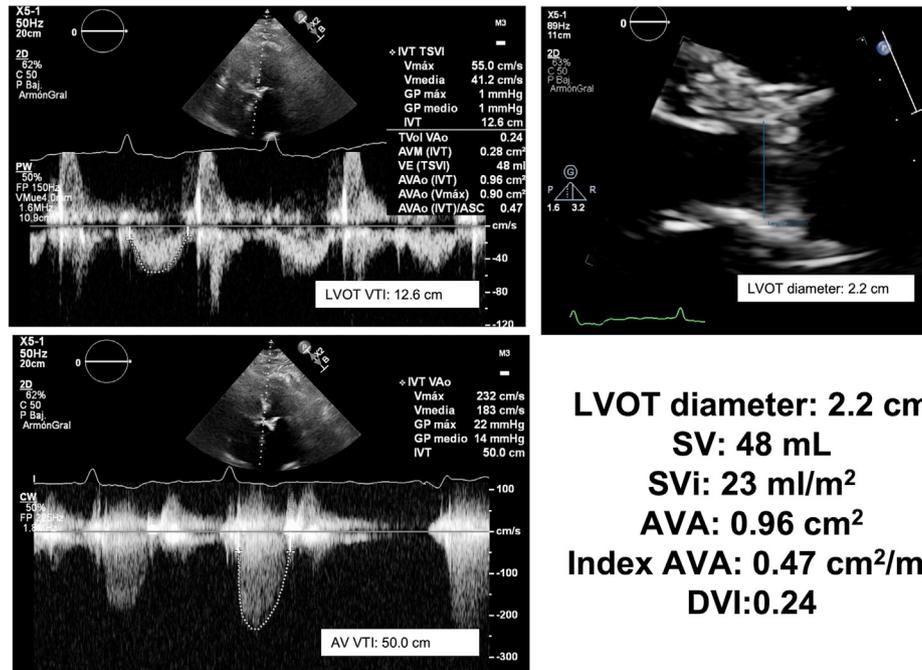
Two-dimensional TTE-guided pulsed-wave (*top left*) and continuous-wave (*bottom left*) Doppler data findings: aortic $V_{\max} = 2.3$ m/sec, MG = 14 mm Hg, AVA = 0.96 cm², indexed AVA = 0.47 cm²/m², SV = 48 mL, SVi = 23 mL/m², and DVI = 0.24. Zoomed parasternal long-axis image of the LVOT diameter (*top right*) demonstrates a maximal diameter of 2.2 cm.
